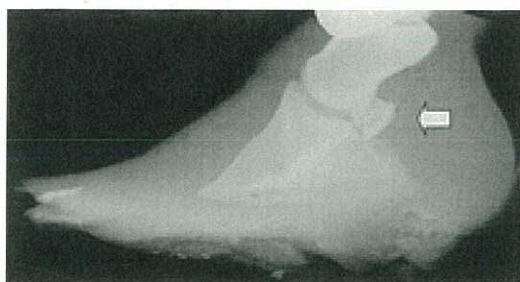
An X-ray image of a hoof. Imaging conditions: 70 kV, 0.6 mAs. The arrow indicates the navicular bone.
